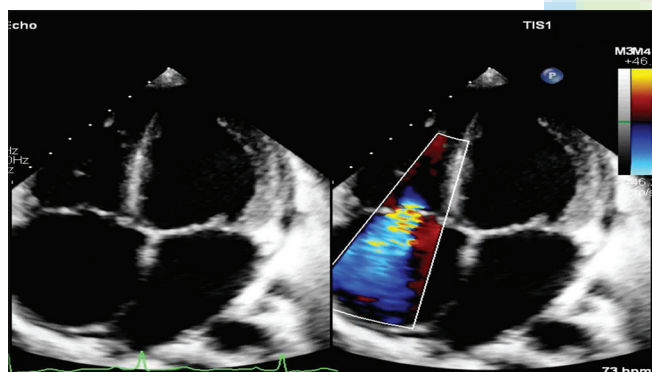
Apical four-chamber echocardiographic view showing prominent dilation of right atrium with bulging of inter-atrial septum to the left and moderate tricuspid regurgitation.
